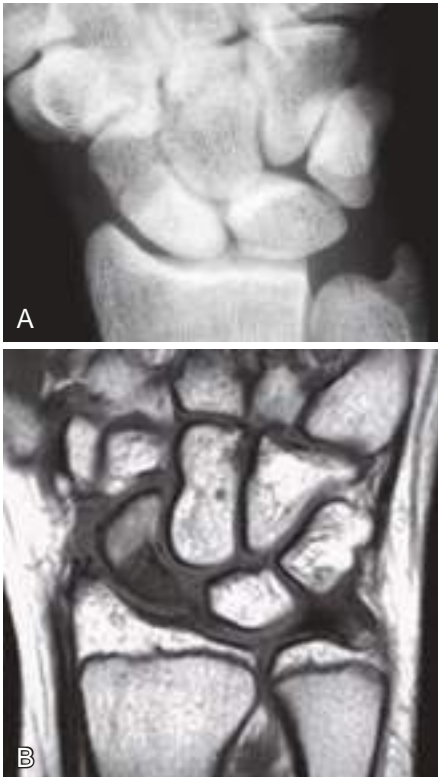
Posttraumatic avascular necrosis. (A) AP wrist radiograph obtained after a nondisplaced scaphoid fracture shows dense proximal pole due to lack of hyperemic healing response. (B) Coronal T1-weighted MR image in a different patient shows lack of normal fat signal in the proximal pole because of avascular necrosis.
